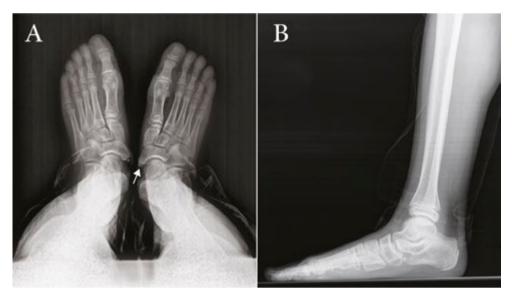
10-year-old boy with accessory navicular type II (arrow) associated with pes planus. A: AP-radiograph shows midfoot pronation and forefoot abduction. B: lateral weight-bearing radiograph shows hindfoot equinus.
